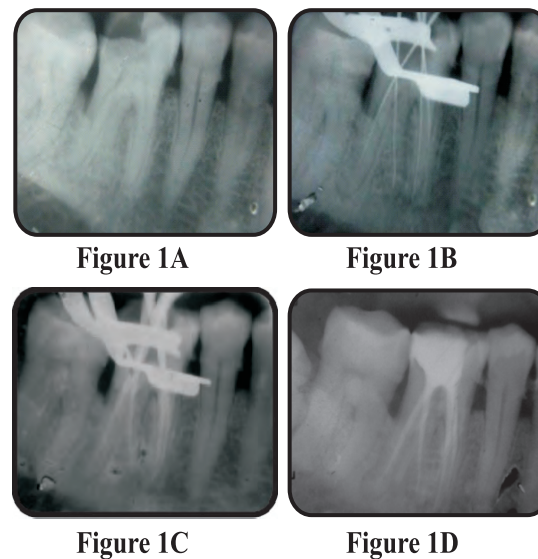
A. Preoperative radiograph of 46 showing the presence of additional distal root.
